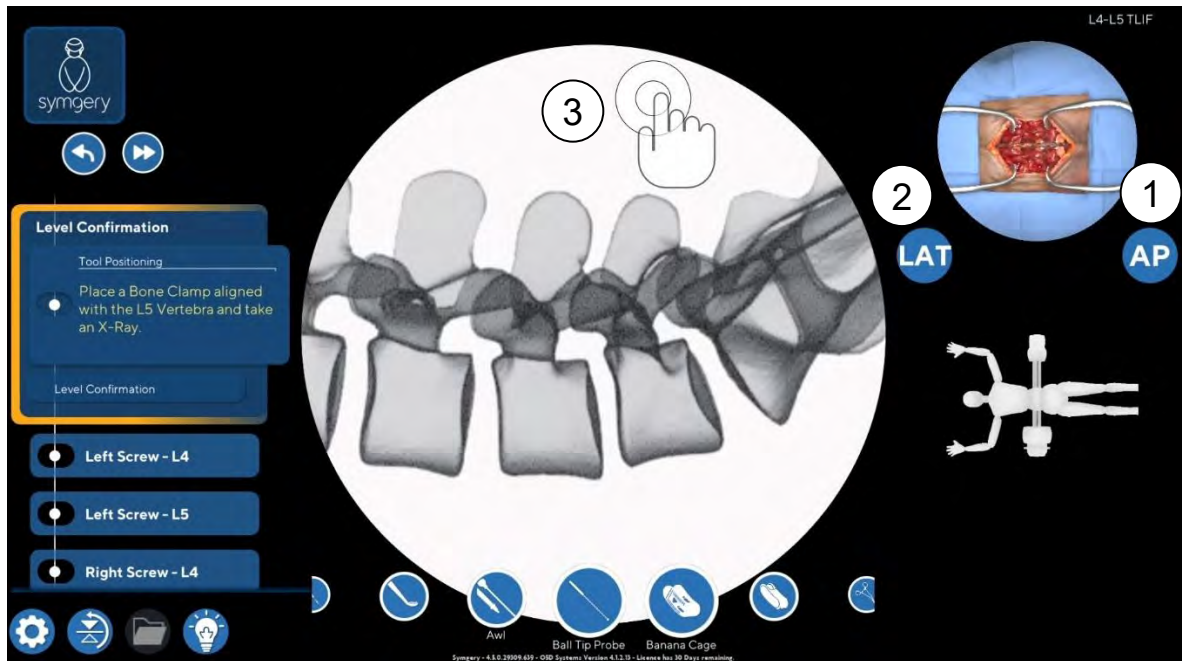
X-ray Lateral (LAT) view example with L4-L5 TLIF Technique.
